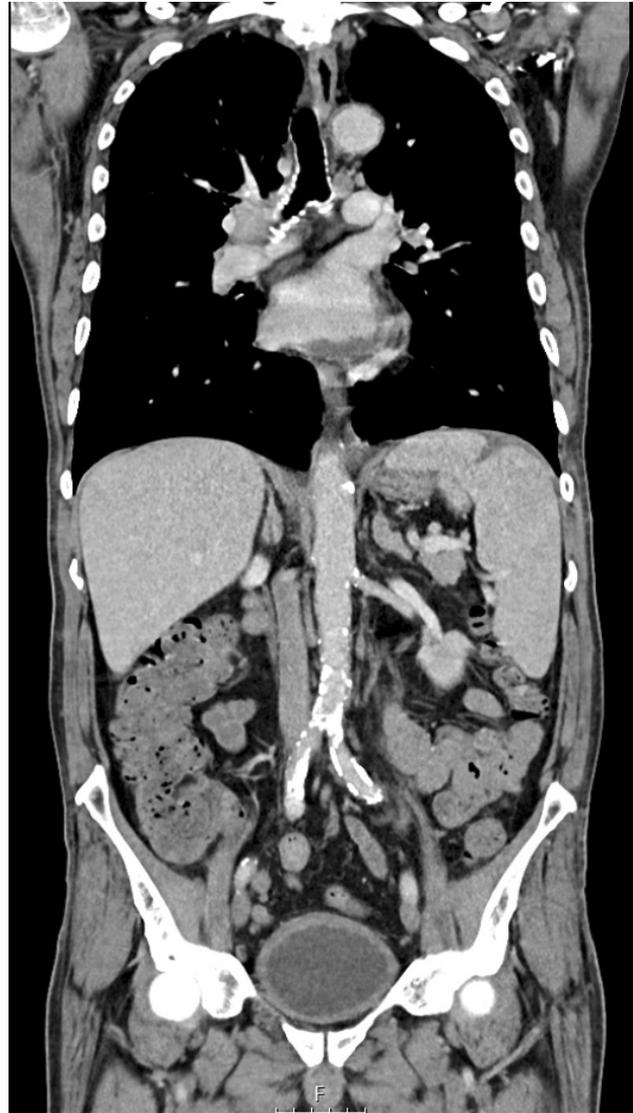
Abdominal-CT scan revealing an enlarged spleen and an area of infarct in its superior lobe
